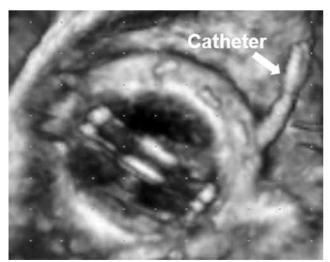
Three-dimensional transesophageal echocardiography showing the diagnostic catheter crossing through the annular dehiscence into the left atrium.
